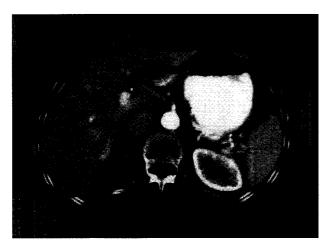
Computed tomographic scan showing isolated liver metastasis from the lung, located at segment VII.
